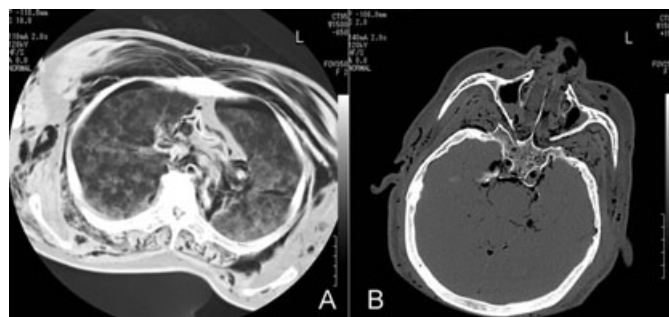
A case of suspected drowning. A 72-year-old man with a history of cervical spine surgery was found lifeless in an irrigation ditch. Based on the circumstances, the police suspected no foul play. A forensic autopsy could not be legally ordered. Our computed tomography scan showed a ground-glass appearance in the lungs that was independent of gravitational forces (A), and a small amount of fluid was trapped in the paranasal sinuses (B). The summer season hastened decomposition of the body, and putrefactive gas was observed subcutaneously just 1 day after death.
